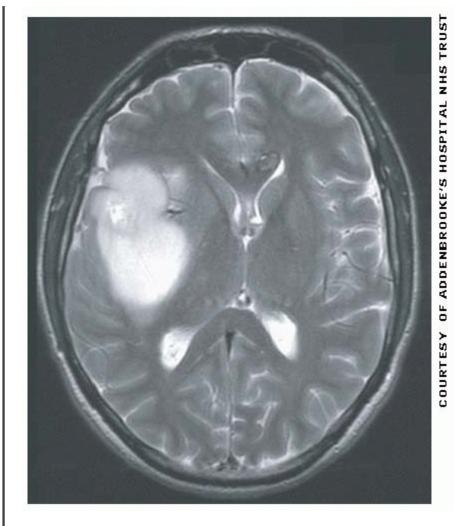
Axial T2 weighted MRI of the same patient at the same level. The high signal in the temporo-parietal region with more central focal high signal again shows mass effect. The diagnosis was of a cystic tumour. Note that on this T2 weighted image the cerebrospinal fluid within the ventricles and cortical sulci are of high signal due to their high water content.
